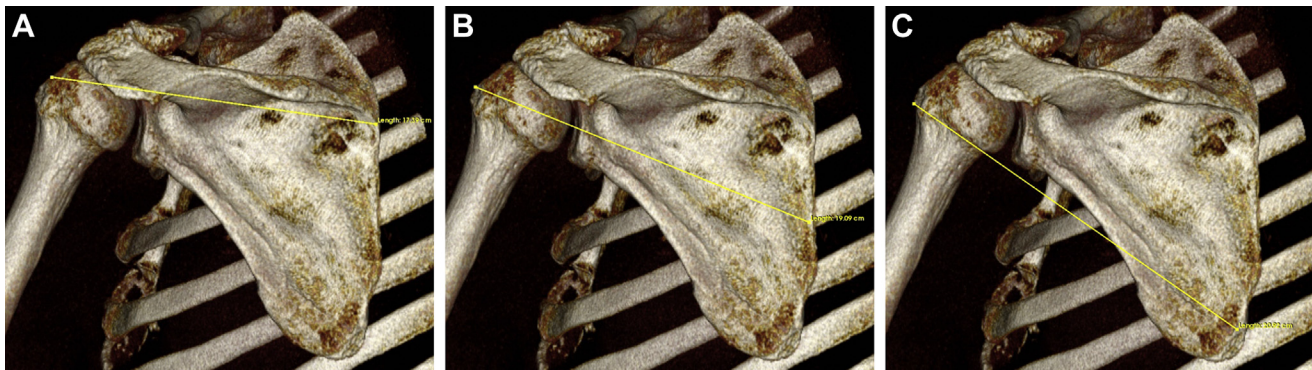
A 3-dimensional reconstruction of a computed tomographic scan of the shoulder, viewed posteriorly, demonstrating the measurement technique for the (A) upper (B), mid-, and (C) lower infraspinatus.
